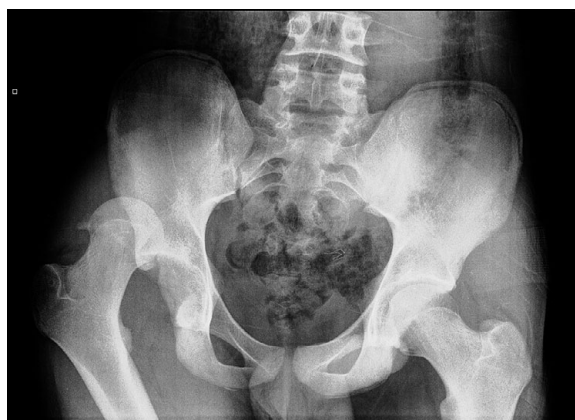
Anteroposterior (AP) radiograph hip
